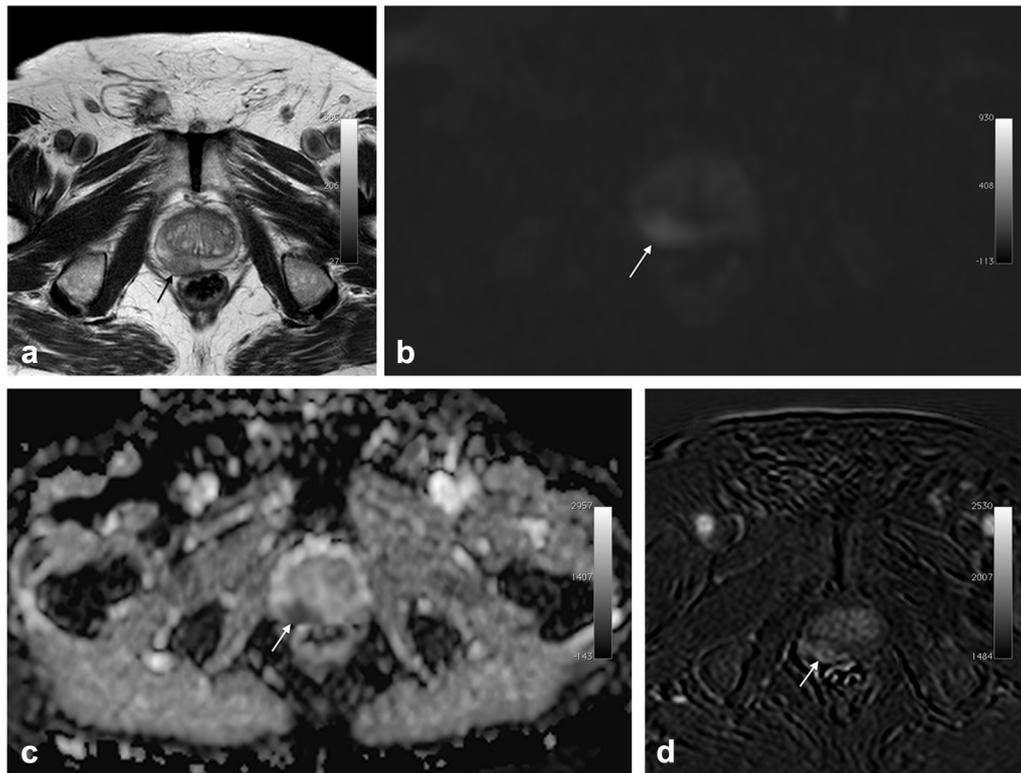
(a–d) MR imaging of the prostate before chemoembolization depicting a PCa (Gleason 4 + 4; PSA of 12.2 ng/mL) in the right peripheral zone of the prostate (arrows). (a) Hypointense on axial T2-weighted image. (b) Hyperintense with diffusion restriction (b1400). (c) Hypointense on apparent diffusion coefficient map. (d) Hypervascular nodule with perfusion imaging.
